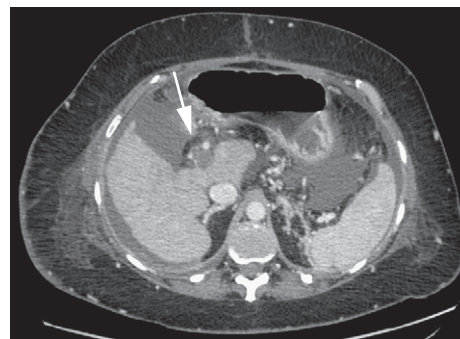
Helical computed tomography showing complete obstruction of the main trunk of portal vein (white arrow) by a cruoric thrombus in a patient with alcoholic cirrhosis.
